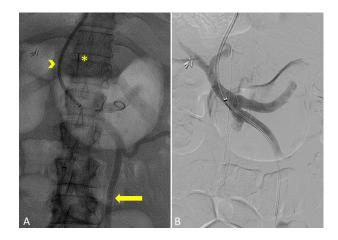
Transjugular intrahepatic portal access. Fluoroscopic (A) and digital subtraction angiography (B) images of the portomesenteric venous access show a long 10F sheath (arrowhead) coursing from the middle hepatic vein to the left portal vein then into the main portal vein. The IMV (arrow) is enlarged and demonstrates retrograde flow. An IVUS probe (asterisk) was placed into the intrahepatic inferior vena cava to guide the initial needle access into the portal system. IMV, inferior mesenteric vein; IVUS, intravascular ultrasound.
